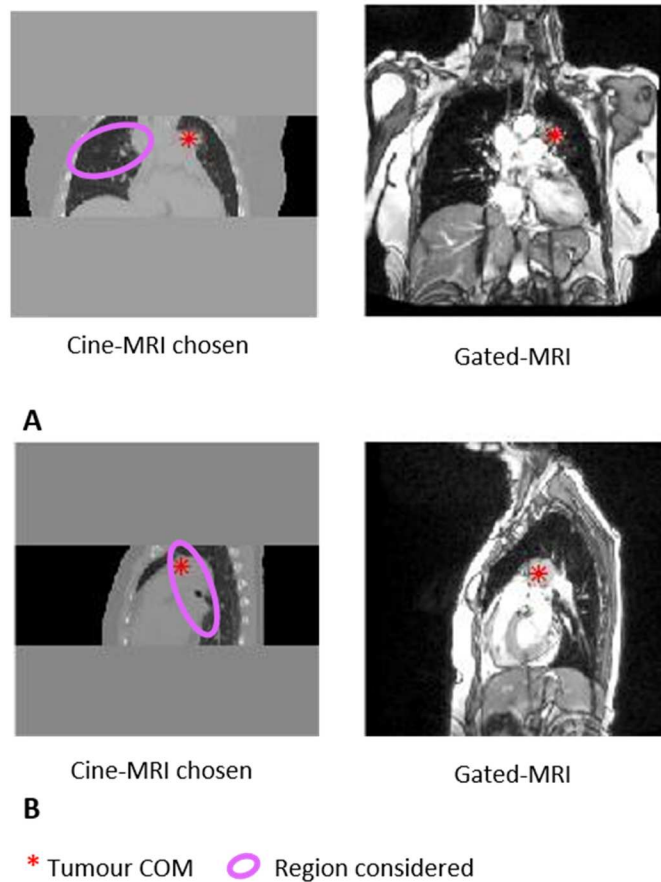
Pre-treatment surrogates-Patients: surrogates extracted from 4D CT. A-patient A. B-patient B. C-patient C.
